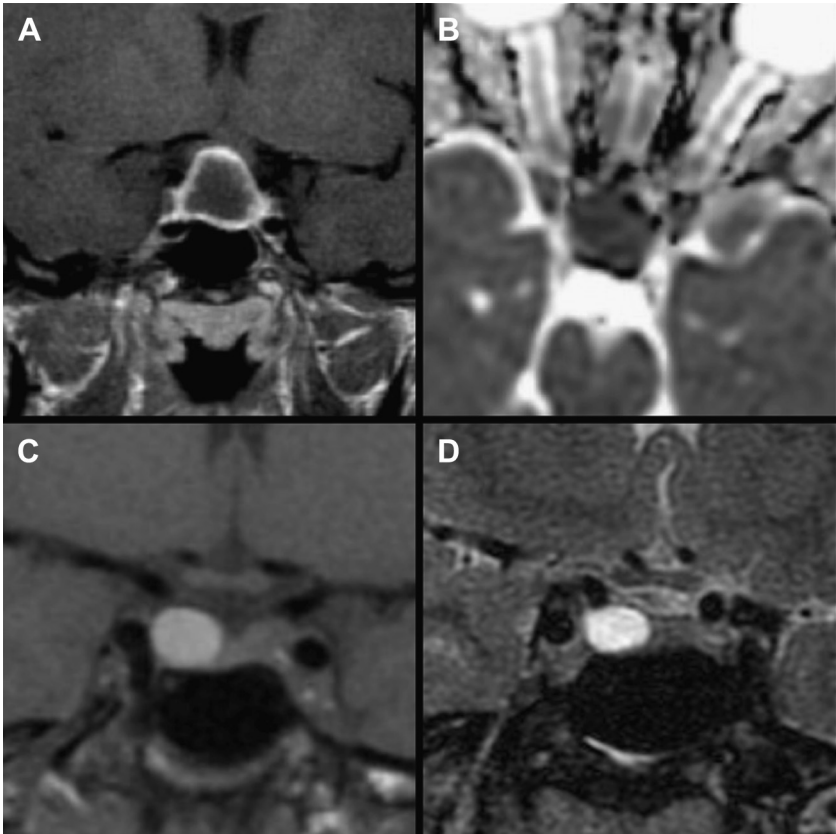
Cystic sellar masses. Gadolinium-enhanced T1 (A) and axial apparent diffusivity map (B) in a patient with intrapituitary abscess. Irregular enhancement of the abscess wall and reduced diffusion distinguish this lesion from other cystic lesions in the pituitary gland. (C) High T1 signal within a hemorrhagic adenoma on unenhanced T1-weighted image, which resolved on follow-up. (D) Cystic adenoma showing high T2 signal laterally within the pituitary. Only 10% of Rathke cleft cysts are located off the midline.
